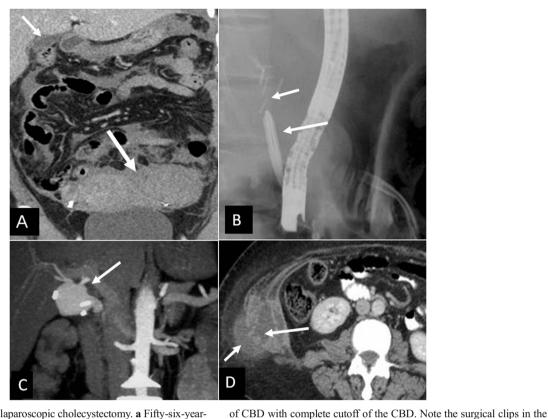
Complications of laparoscopic cholecystectomy. a Fifty-six-yearold female presents with a painful abdomen 3 days after laparoscopic cholecystectomy. Coronal contrast-enhanced CT demonstrates a large omental hematoma (*long arrow*) related to laparoscopy port insertion. Note the postcholecystectomy changes in the gallbladder fossa (*short arrow*). b Laparoscopic cholecystectomy complicated by clipping of the proximal-mid-CBD in a 45-year-old woman. The guide wire (*long arrow*) during ERCP could not be passed beyond the clipped segment
